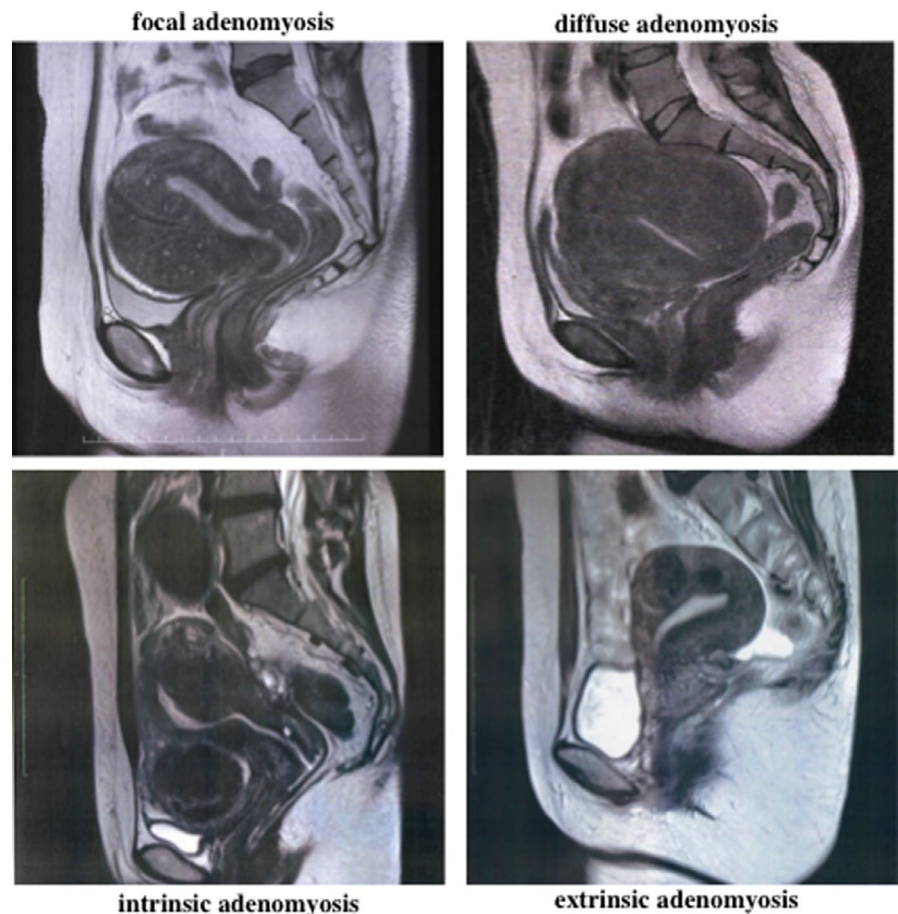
T2-weighted magnetic resonance images (sagittal section) of focal adenomyosis (upper left panel), diffuse adenomyosis (upper right panel), intrinsic adenomyosis (lower left panel), and extrinsic adenomyosis (lower right panel) are shown. An explanation of each subtype of adenomyosis is described in the text
